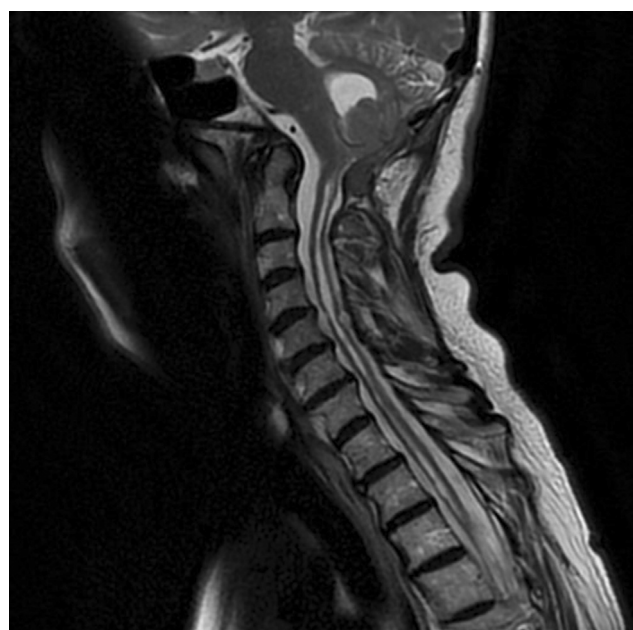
T2 sagittal magnetic resonance imaging showing near-complete resolution of the syrinx throughout its length.
